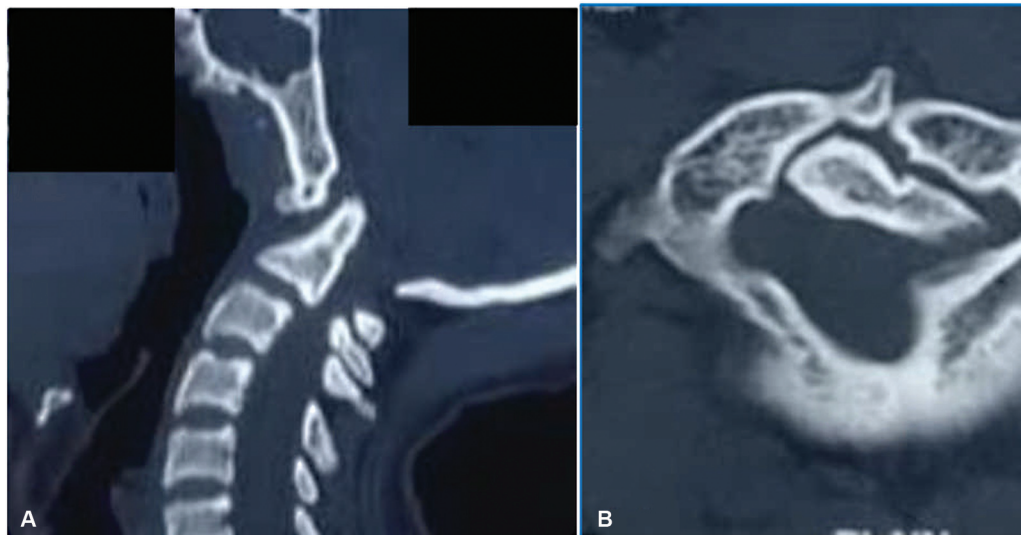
Preoperative computed tomography scan of craniocervical junction with upper cervical spine, (A) sagittal and (B) axial section, showing atlantoaxial dislocation with rotation of the occipitoatlantal joint having a bifid anterior and posterior arch of atlas (C1).
